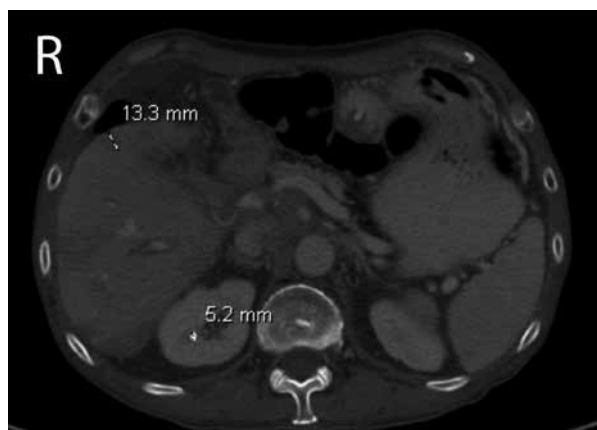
CT scan of abdomen. CT: Computed tomography; R: Right side.
